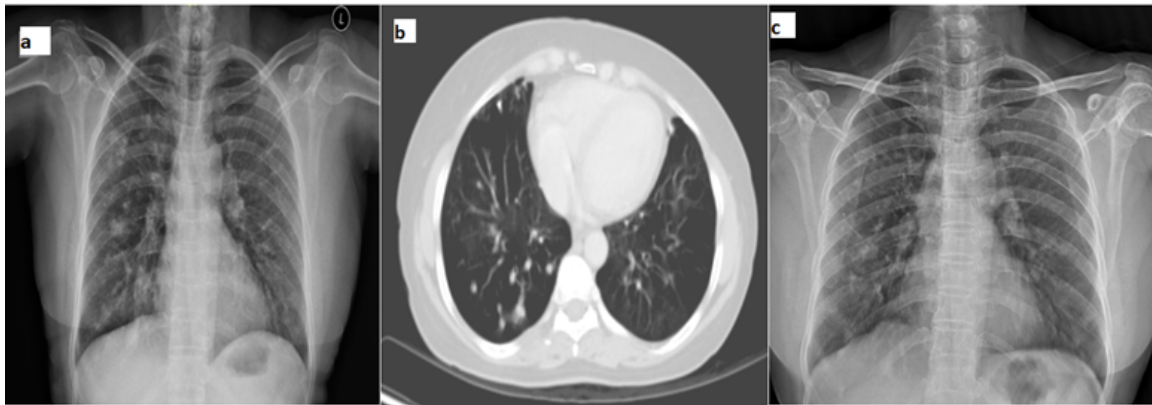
Case 1 a: Chest X-ray showed ill-defined and irregular nodular opacities in right side lung mid zone, lower zones, and left lower zone; b: Contrast enhanced computed tomography of thorax which showed multiple nodules in bilateral lungs (Right>left); c: Post-treatment chest X-ray showing resolution.
